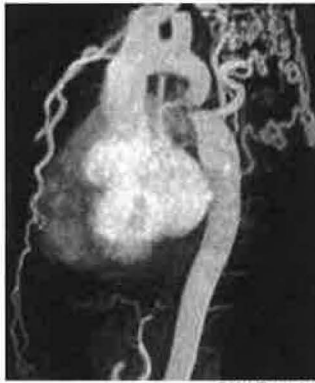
Sagittal oblique gadolinium enhanced maximum intensity projection MR image. There is a focal narrowing of the descending aorta in the region of the ligamentum arteriosum (juxtaductal) with post-stenotic aortic dilatation. There are multiple collateral vessels into the descending aorta via internal mammary and intercostal arteries. From <http://download.imaging.consult.com/ic/images/S1933033207745421/gr2-midi.jpg>
